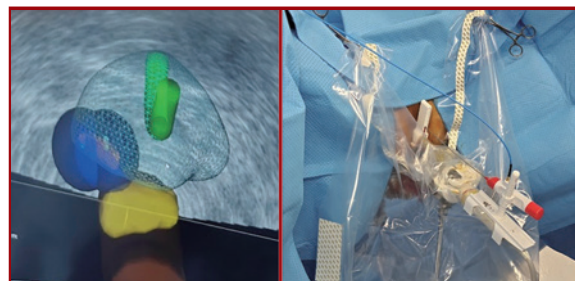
Microwave ablation. (Left) Software fusion of transrectal ultrasound and magnetic resonance imaging, depicting the locations of the urethra (green), rectal spacer (yellow), rectum (brown), microwave ablation zones (blue), and the lesion (orange). (Right) Set up with the microwave ablation needle in situ (Clinical photos from personal collection)
